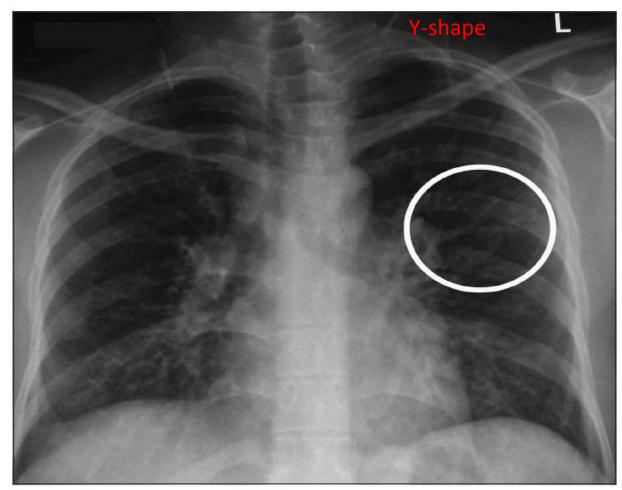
Chest radiograph shows a "Y-shaped" opacity (circle) that represent mucus-filled bronchi
